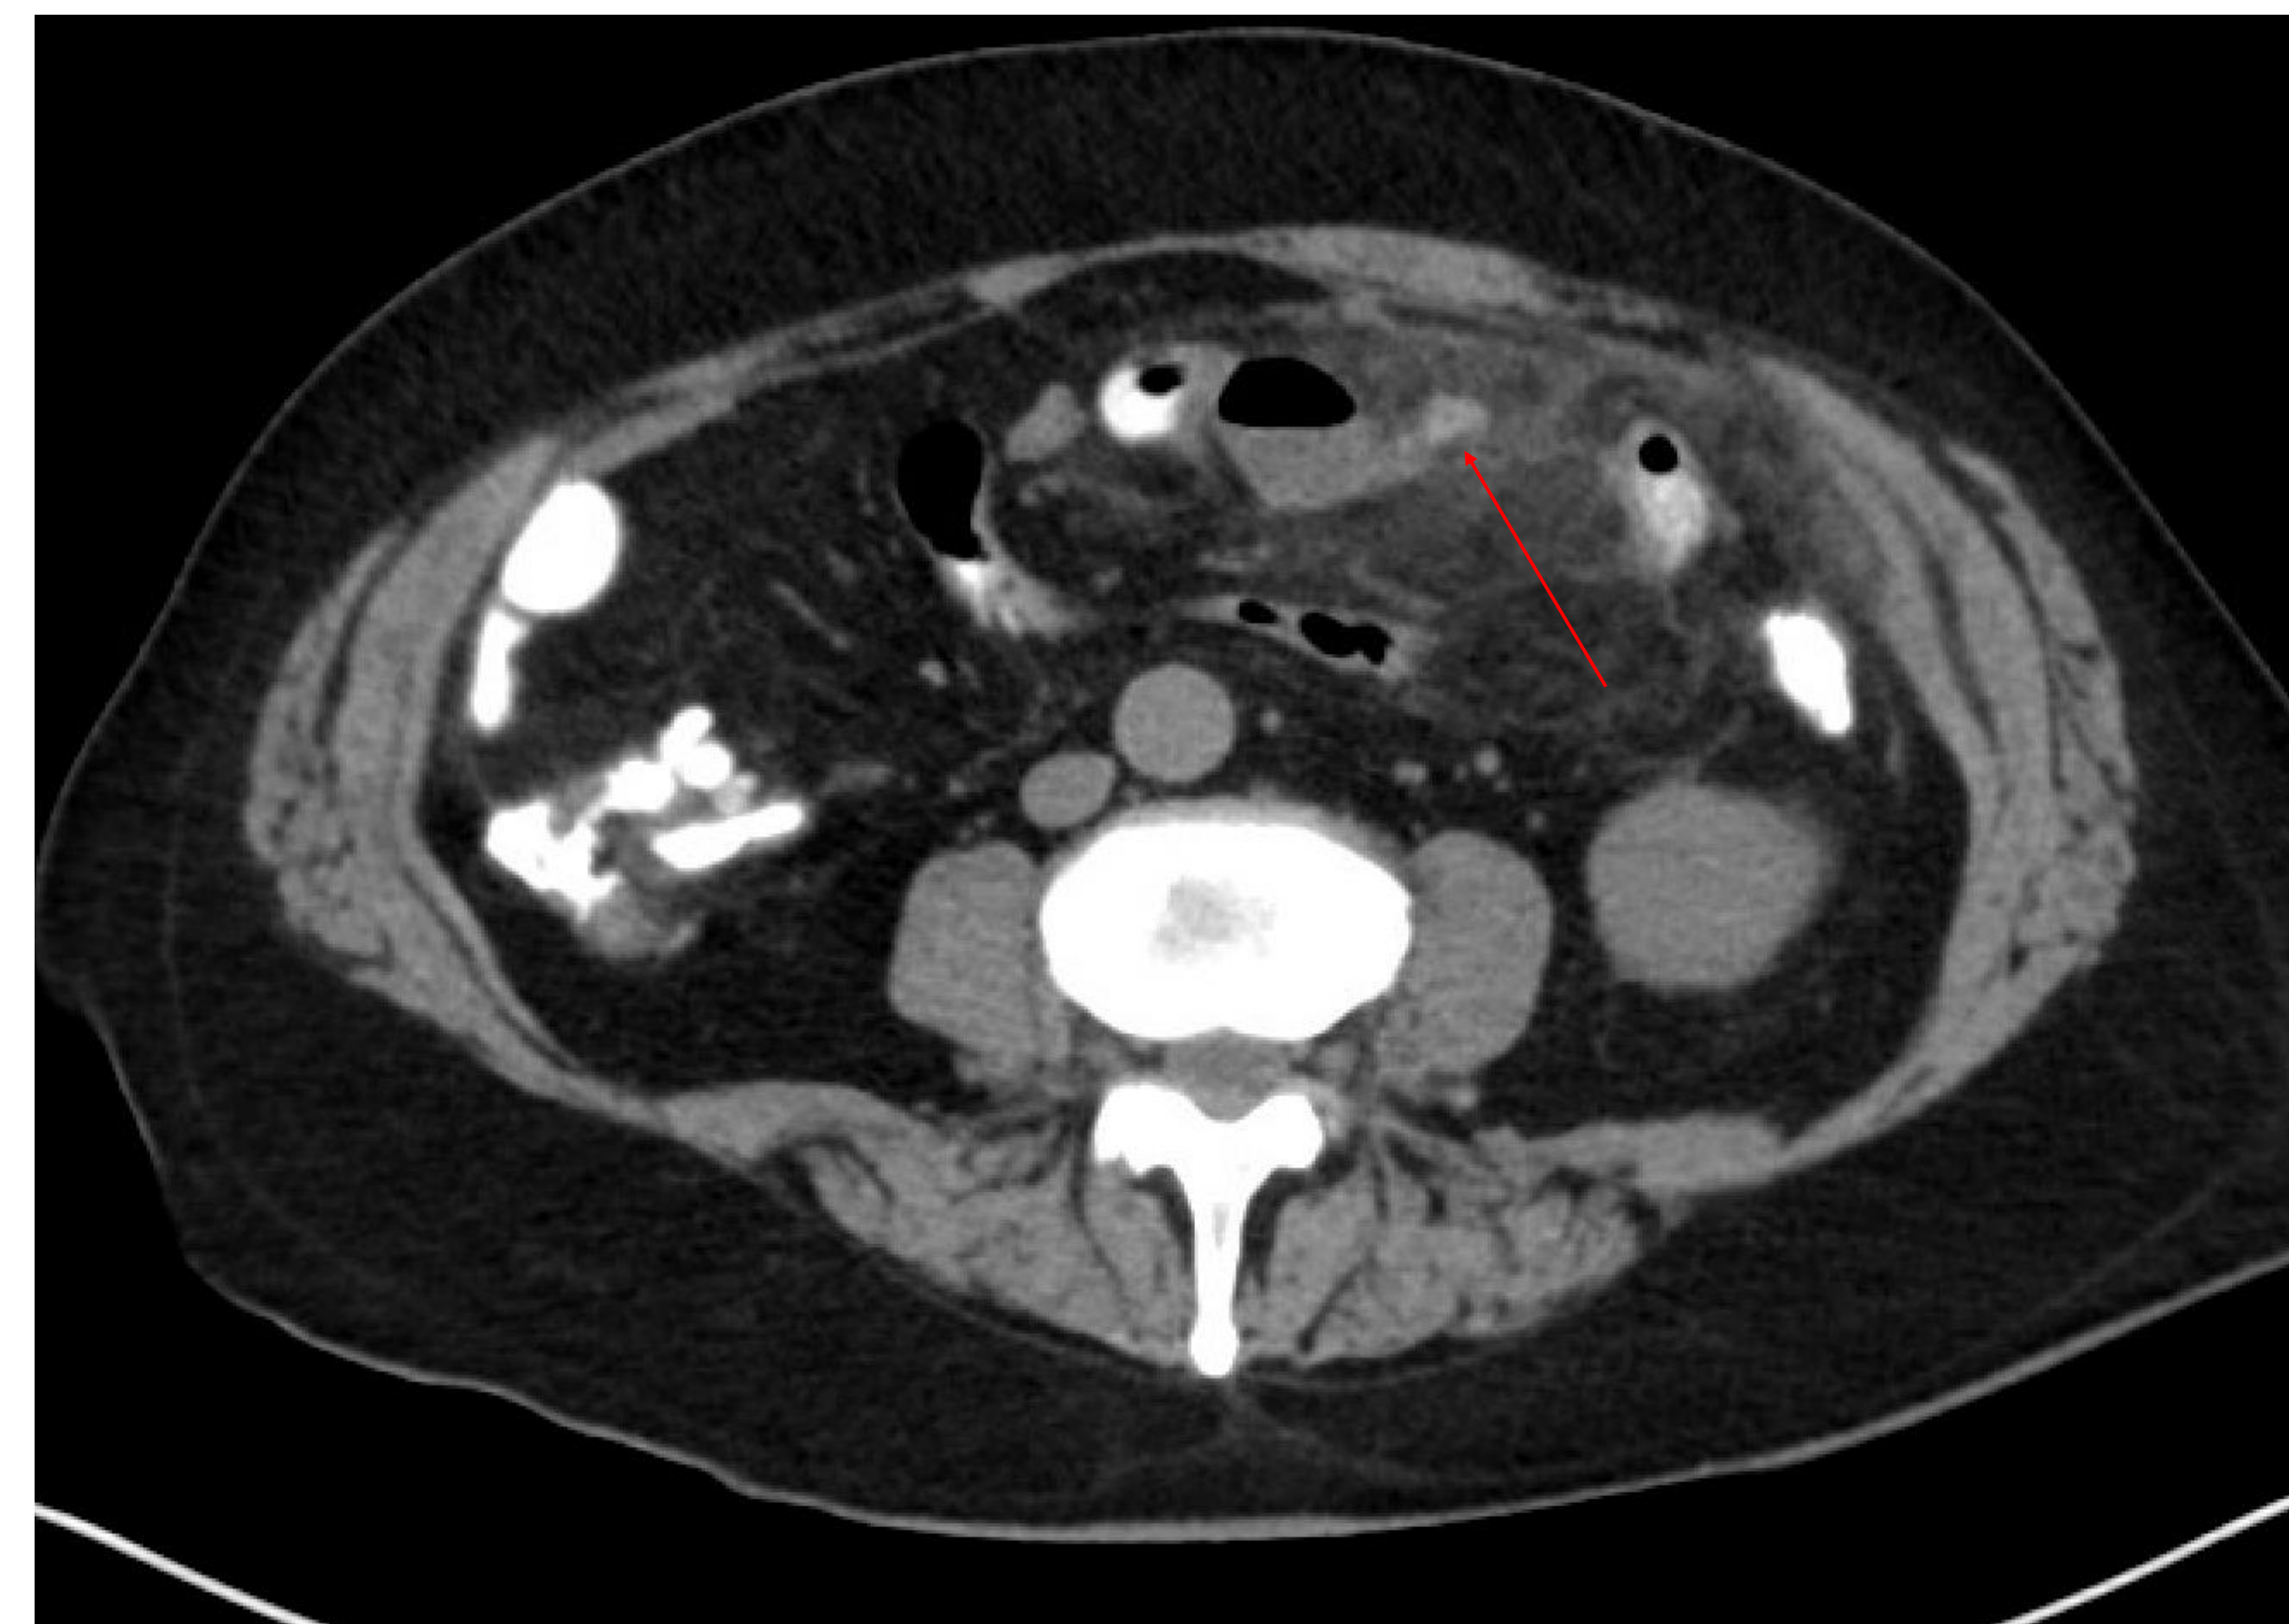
CT Abdomen/Pelvis transverse view showing jejunal perforation with surrounding inflammation (arrow).
